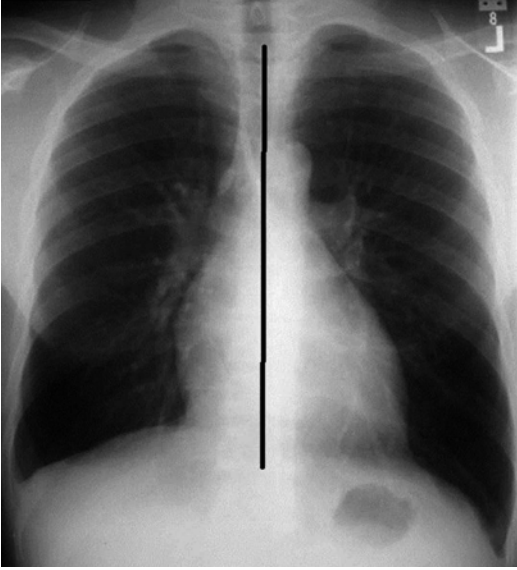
Standard posteroanterior chest X-ray, showing a normal heart, which is a left-sided heart with a leftward-pointing apex
